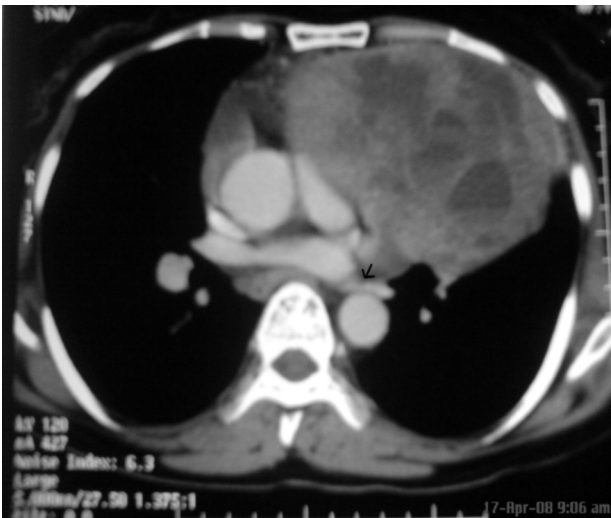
CT chest showing a large non-enhancing cystic lesion in the mediastinum with hypodense and hyperdense areas and origin of pedicle in the posterior mediastinum.
